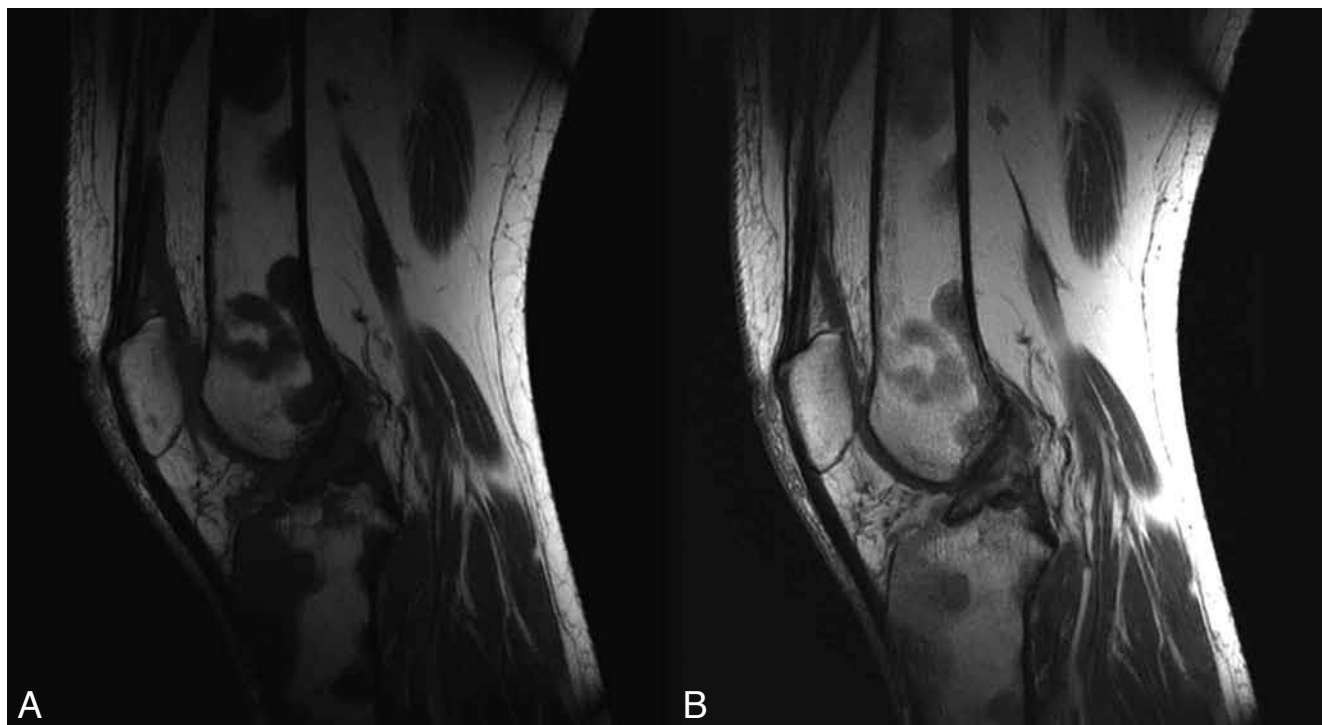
A. MRI of the knee shows irregular zones with low signal on the T1 non-contrast enhanced image, sparing the epiphysis. B. These lesions had contrast enhancement on the T1 sequence after intravenous injection of Gadolinium.
